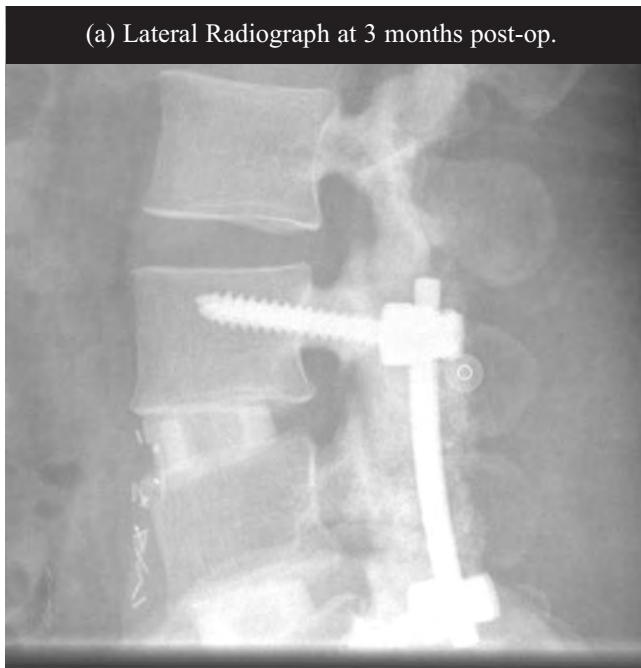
(a) and (b) Lateral Radiograph
